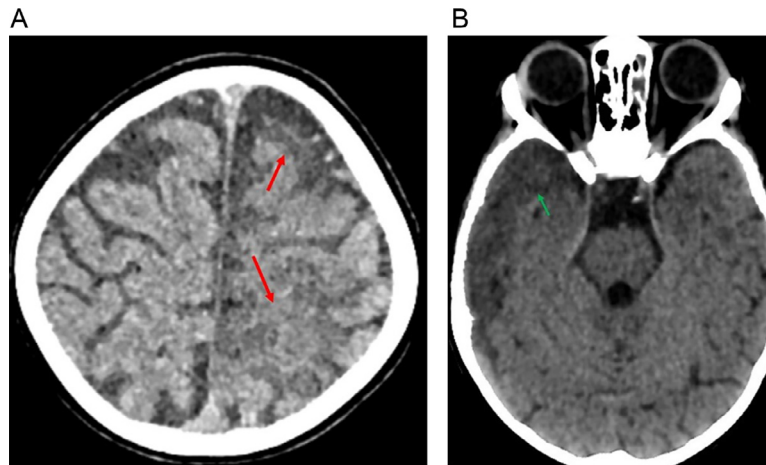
(A) Noncontrast axial brain CT scan showing cortico-subcortical hypodensities in the left fronto-parietal regions that do not correspond to any vascular territory. (B) Noncontrast axial brain CT scan in axial cuts, performed after 3 weeks, showing a right cortico-subcortical temporal hypodensity not observed in the previous exam that do not correspond to any vascular territory (green arrow).
